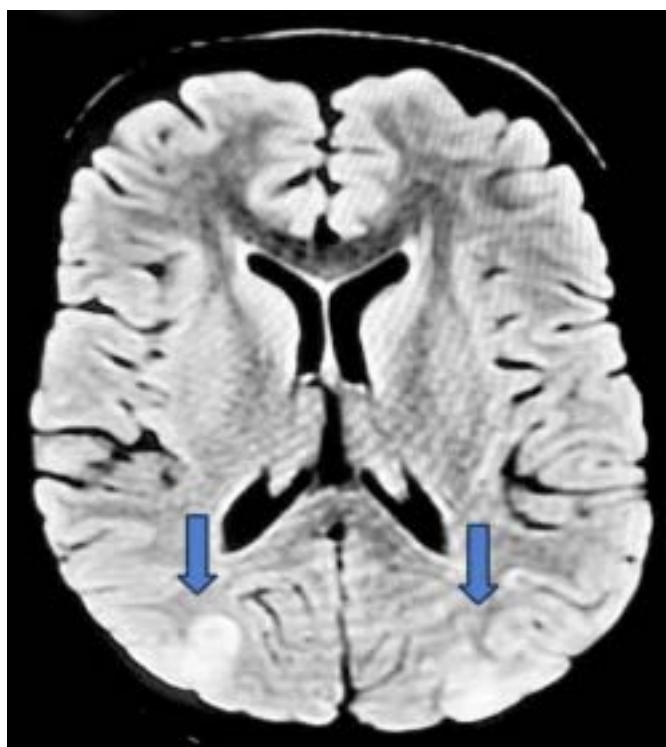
T2W – FLAIR MRI Patchy area of hyperintensity in cortical subcortical location of parieto-occipital region with faint diffusion restriction
